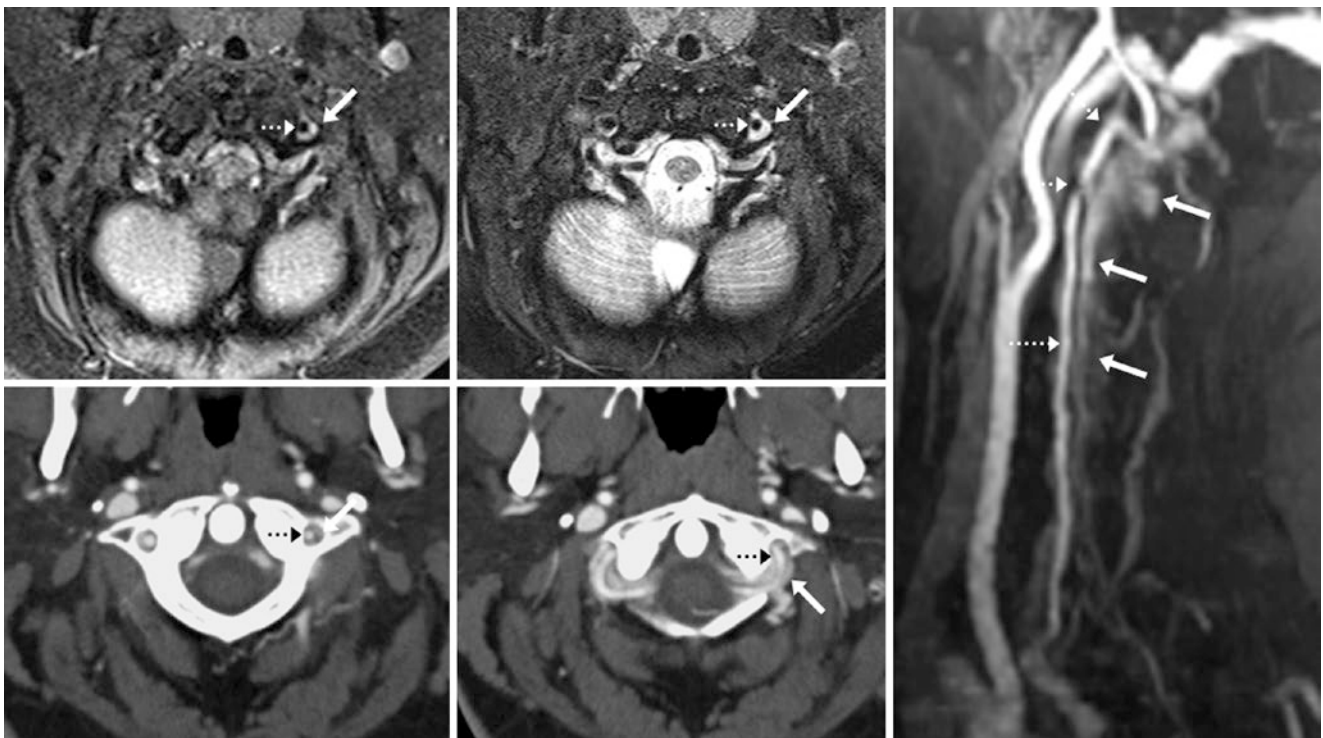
In this 25-year-old, an MRI shows that the left vertebral artery (VA) at the level of C1 (arrows) is surrounded by bright signal on fat-suppressed T1WI (top left) and T2WI (top middle). On a contrast-enhanced MRA lateral view (right), ill-defined enhancement surrounds the left VA (dotted arrows), as contrast is partially in the venous phase, later confirmed to be the vertebral venous plexus (VVP) on CTA source
